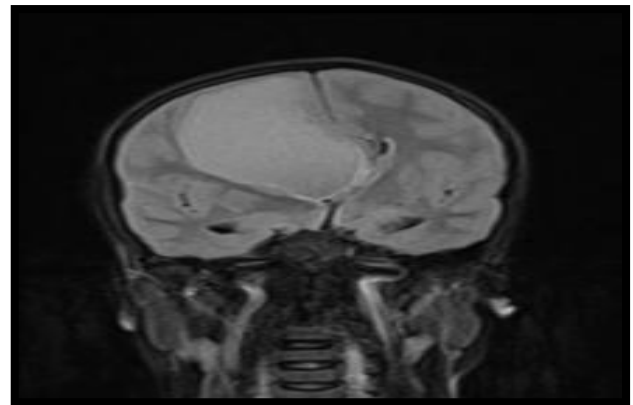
T1-weighted MRI brain (P+C), coronal view showing a cystic lesion in the frontoparietal lobe causing significant compression of the right lateral ventricle.
